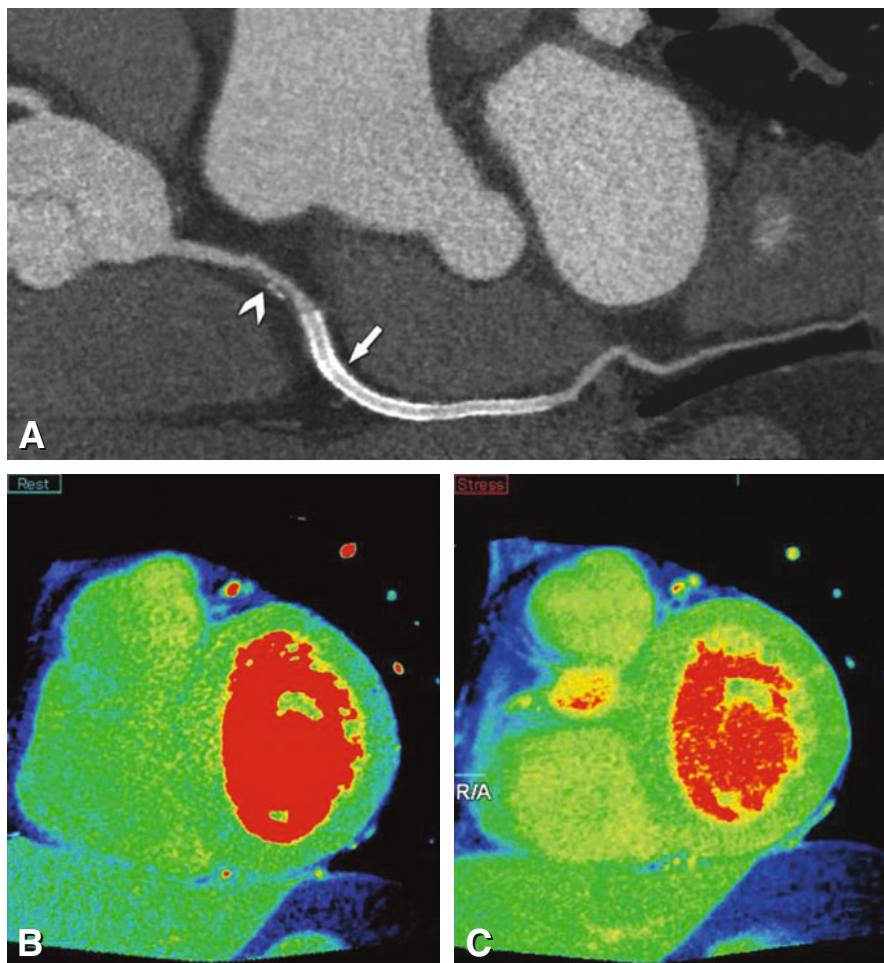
Usefulness of myocardial perfusion imaging using 320-row volume CT in a 67-year-old female patient with atypical symptoms 3 years after stenting of the right coronary artery. Coronary CT angiography shows mostly noncalcified plaque immediately proximal to the stents (arrowhead in Panel A, curved multiplanar reformation). No significant in-stent restenosis can be identified; however, the small size of the stents (arrow, 3 mm diameter) precludes reliable exclusion of significant stenosis. Myocardial perfusion analysis during rest (Panel B) and stress (Panel C) rules out significant defects
